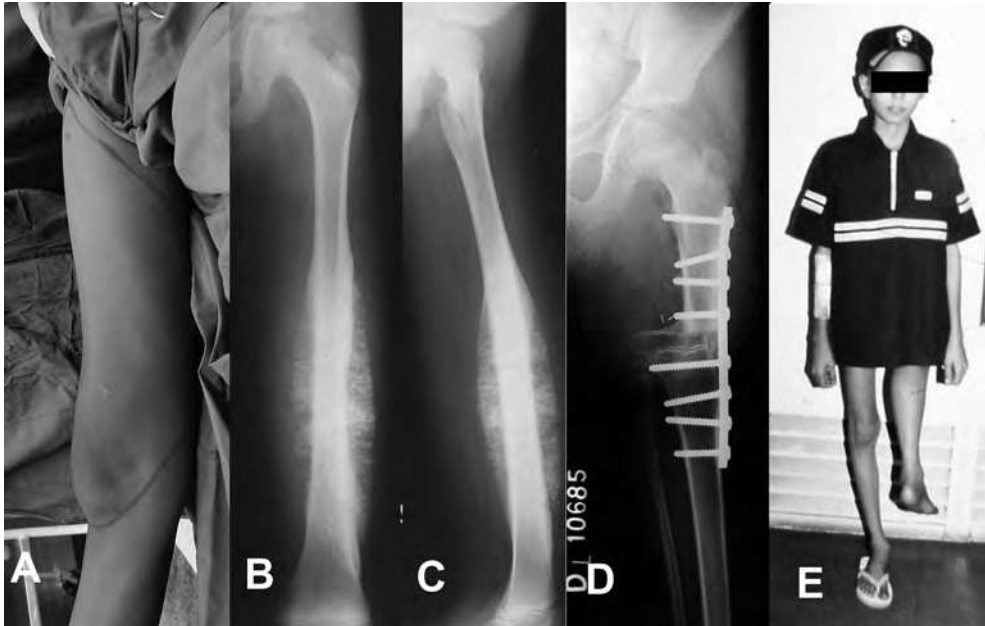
Rotationplasty. A: the rhomboid incision taken. B & C : The Anteroposterior and lateral xrays of a femoral osteosarcoma after induction chemotherapy. D: postoperative xray showing the osteosynthesis between the proximal femur and proximal tibia using a plate. E: The clinical appearance of rotationplasty
